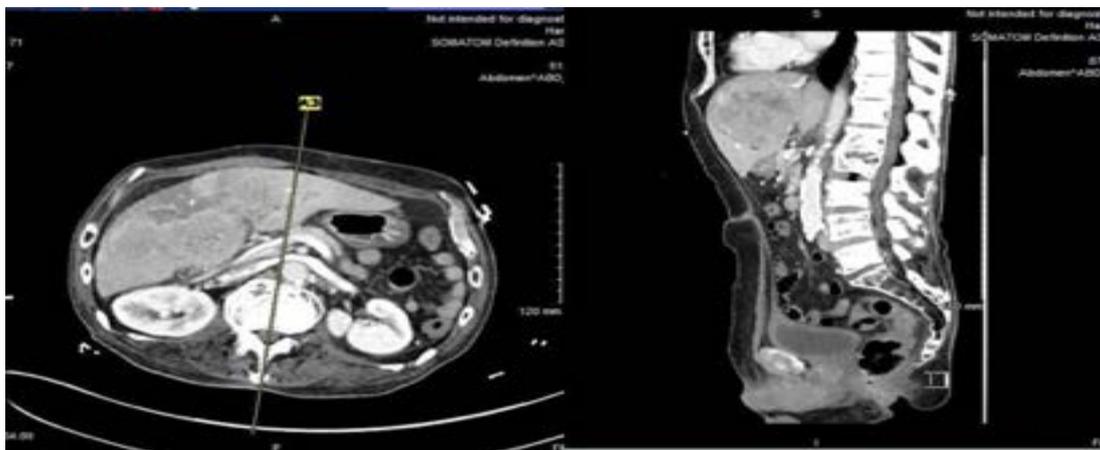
CT scan of abdomen and pelvis showing a large heterogeneous intrahepatic mass
